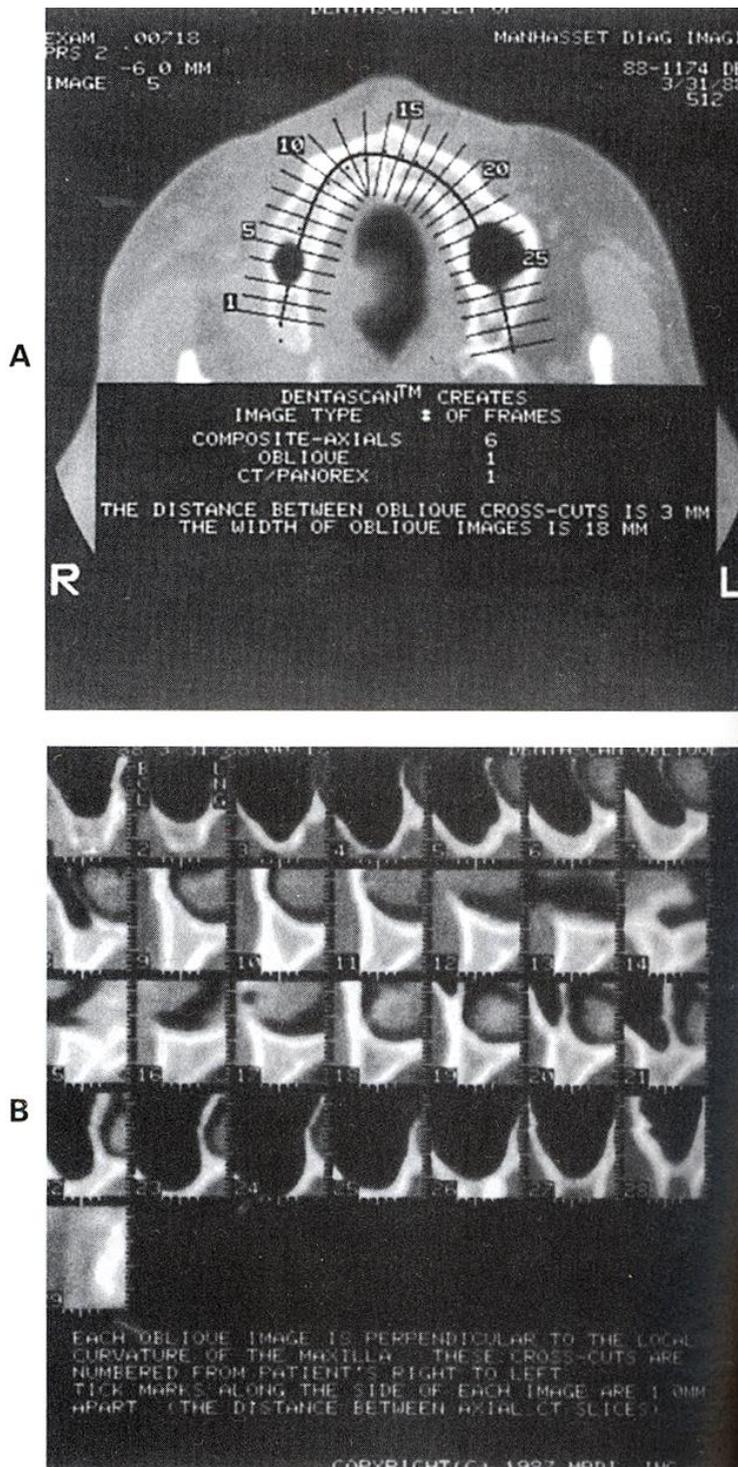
CT scan using software designed specifically for dental implant planning. A, Axial cut with numbered orientation planes that are seen in the corresponding vertical cuts in B.
